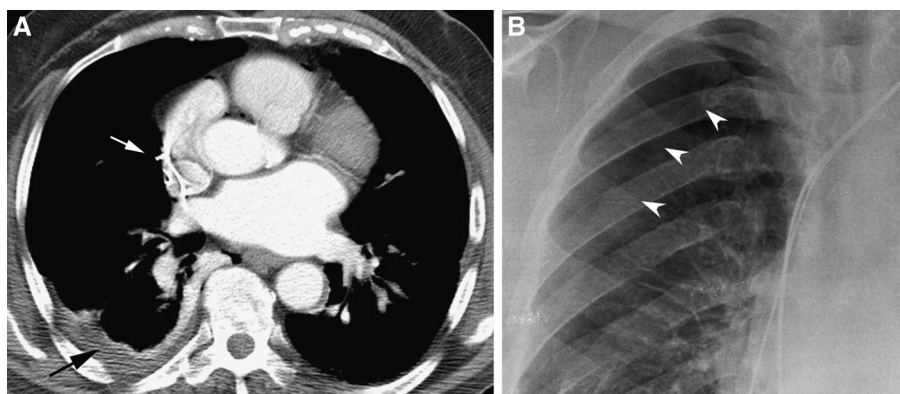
Pacemaker lead perforation. The tip of the atrial lead helix is seen to perforate the wall of the right atrium on axial (A) computed tomography imaging (white arrow) associated with a right-sided hemothorax (black arrow) and pneumothorax (B, white arrowheads).
